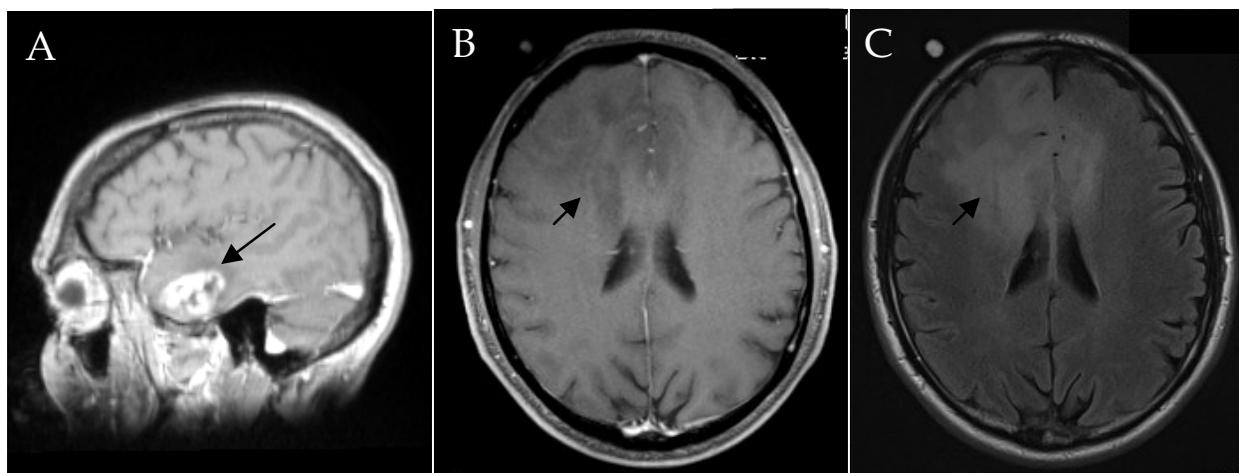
A shows a sagittal gadolinium enhanced MRI scan of a Glioblastoma multiforme (WHO grade IV) with typical gadolinium enhancement of the tumor (arrow). Panel B shows a transversal gadolinium enhanced MRI scan of an Astrocytoma (WHO grade II). No contrast enhancement is noted (arrow). C shows the same tumor as FLAIR weighted image.
